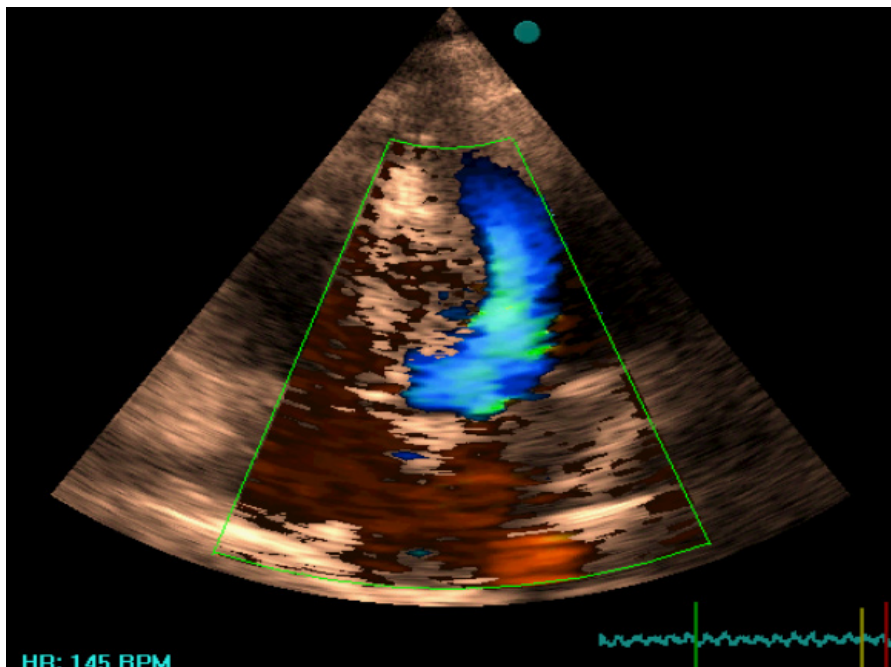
Color Doppler imaging of transthoracic echocardiography demonstrated the lack of blood flow within cystic space and no flow obstruction.
